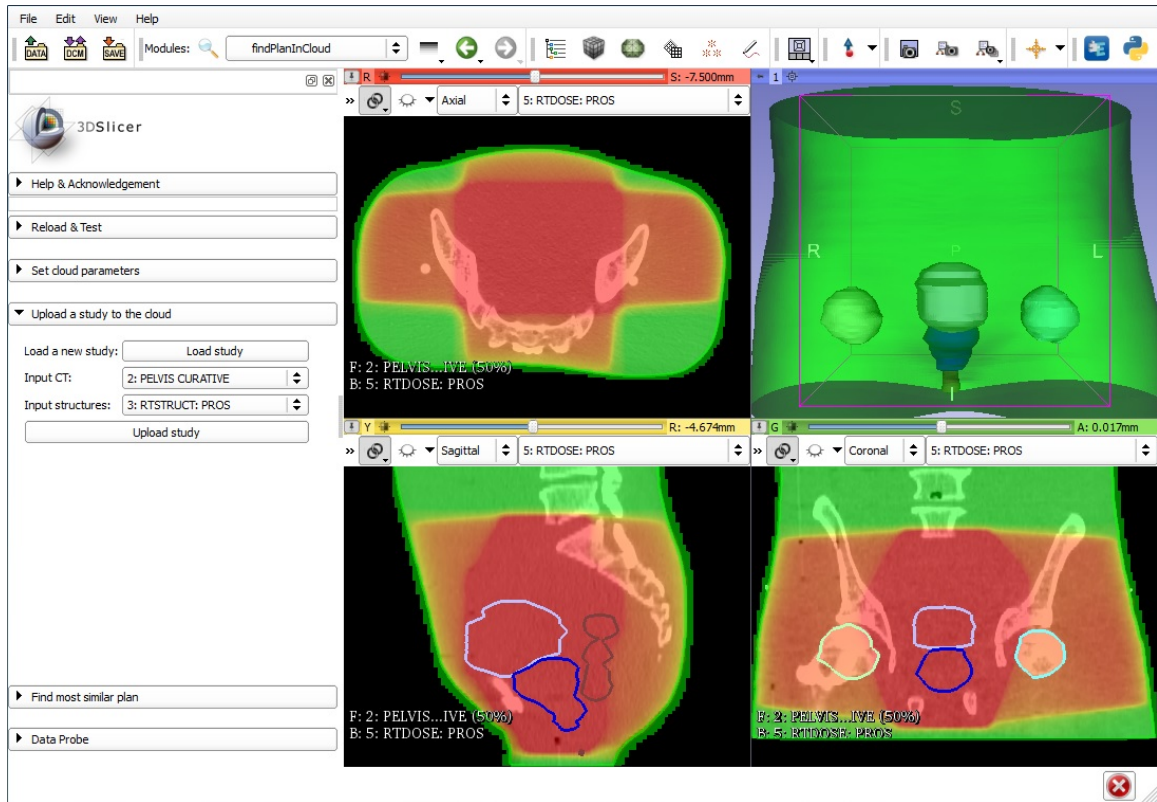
“Upload study to cloud” section of the module with prostate cancer CT and contours loaded and parameters set
